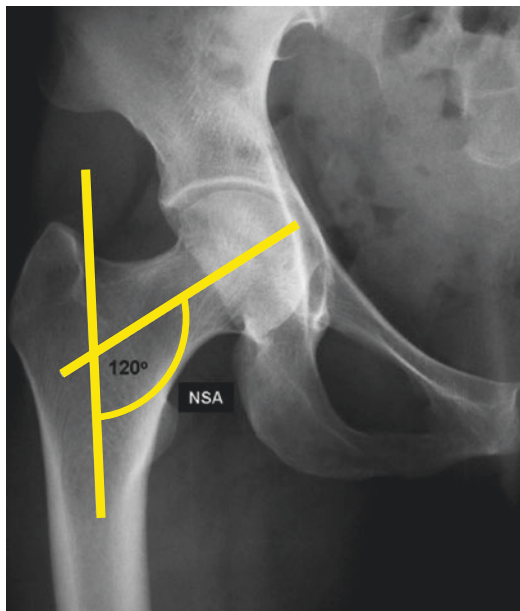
Radiographic measurement of femoral neck shaft angle
